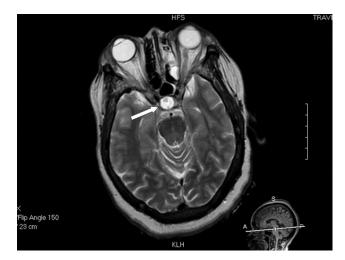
Axial T2-weighted MRI scan demonstrating a completely empty sella (*white arrow*). This structure is a CSF-filled dural evagination into the pituitary fossa. Eighty-five percent of patients with spontaneous CSF leaks in this study had a partially or totally empty sella.
